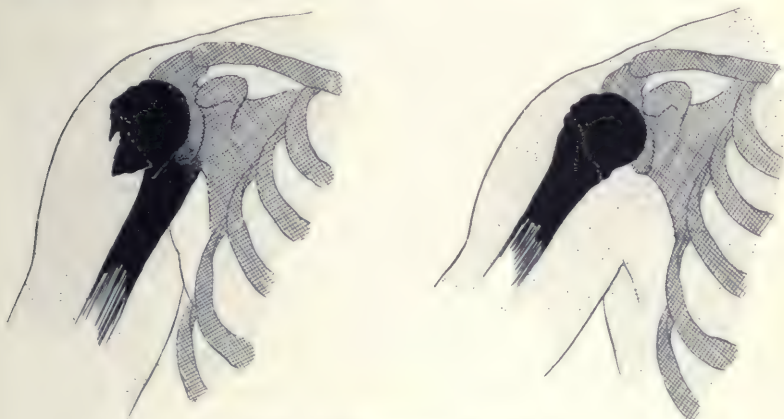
x-Ray tracing of Case II.
